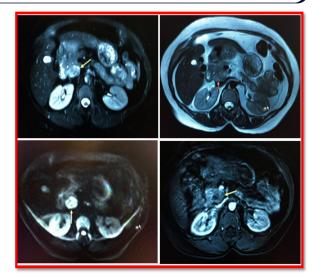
Magnetic resonance imaging images show the mass in T2 SPAIR on top left, T2 on top right, Diffusion weighted image showing restricted diffusion on bottom left and contrast enhanced image with its relationship to renal vein and superior mesenteric vein in bottom right images Positron emission tomography [PET CT] showed a hypermetabolic mass with peripancreatic lymphadenopathy(Figure 3). Endoscopy and endoscopic ultrasound revealed a heterogenous 4 x 3.2 cm lesion. The core biopsy reported FDCSwith CD 21 and CD 23 positivity. As the lesion was very close to thepancreas with no well defined fat plane and peripancreatic lymphadenopathy, the patient was planned for pylorus preserving pancreaticoduodenectomy to achieve R0 resection.
